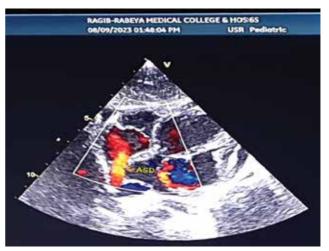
Subcostal four-chamber view with color doppler across the secundum ASD reveals prominent left-to-right interatrial shunting. ASD- Atrial septal defect.
